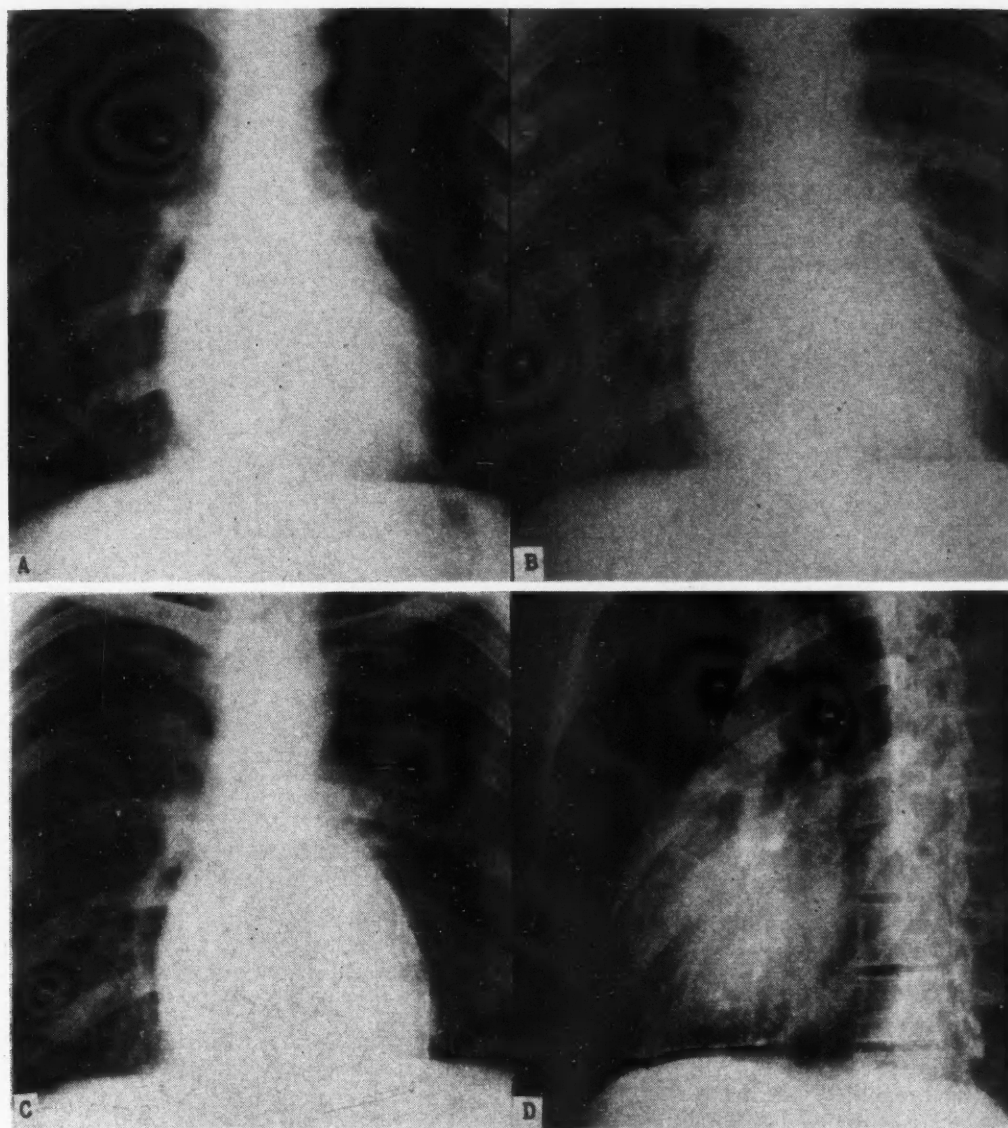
These radiographs of the same patient show the rate at which calcification may occur in the pericardium. (A) 3½ years before operation; (B) 2½ years before operation; (C) and (D) at time of surgery.
